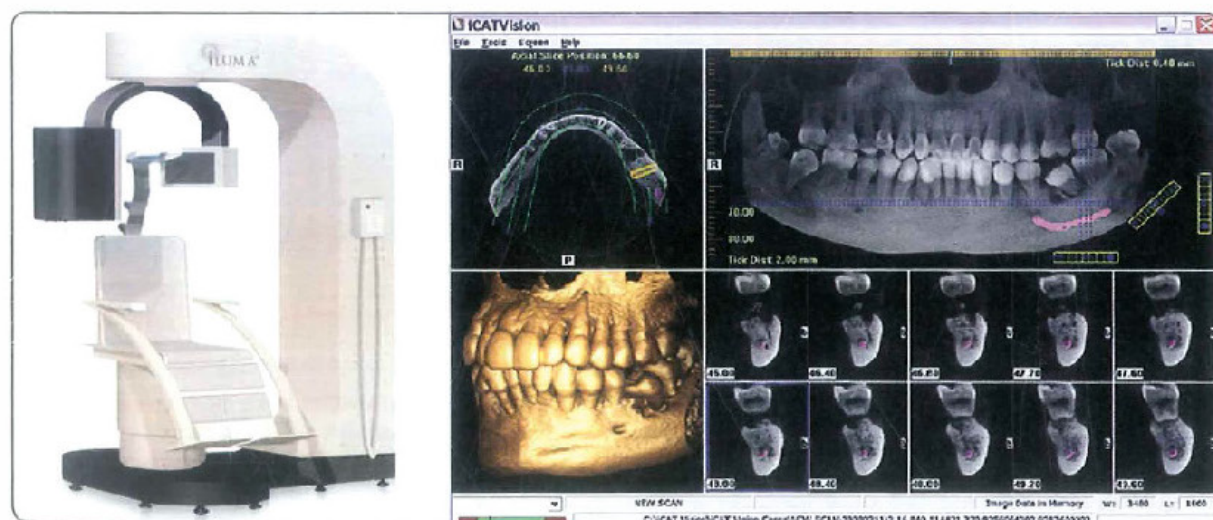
A CBCT machine and a central CBCT scan image
